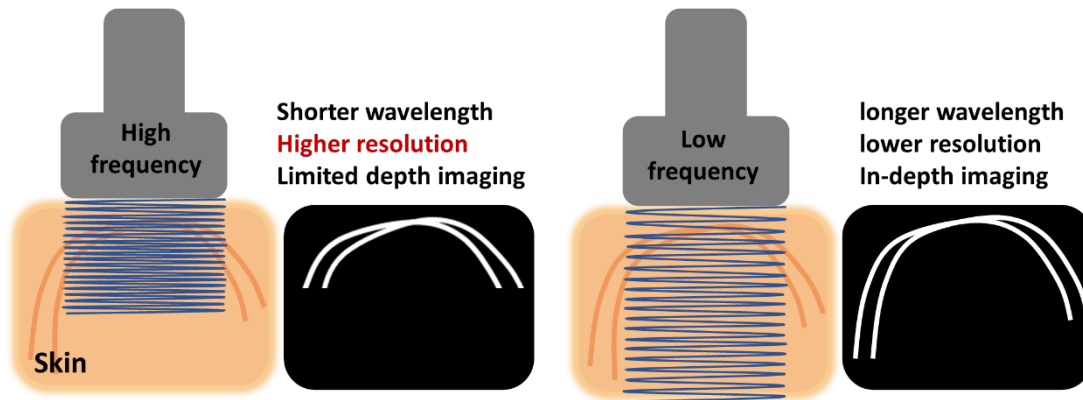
Representation of high-frequency and low-frequency of ultrasound imaging.
